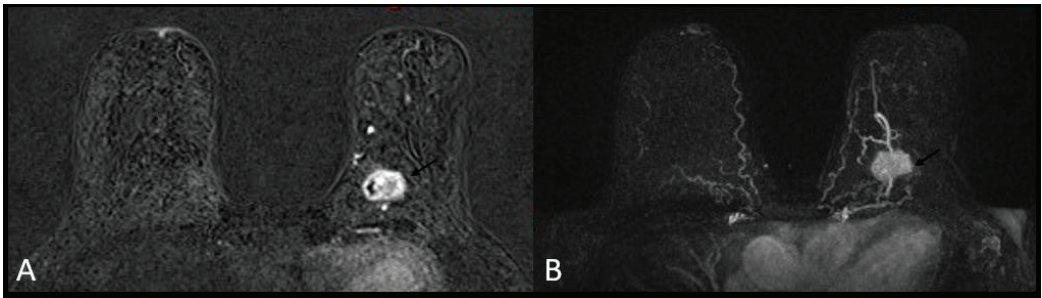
Triple negative breast cancer in a 33-year-old woman—subtracted T1-weighted contrast-enhanced image (A) shows a 3 cm oval (lobulated) mass with circumscribed margins, heterogeneous enhancement and restricted diffusion on DWI (B) and ADC (C).
